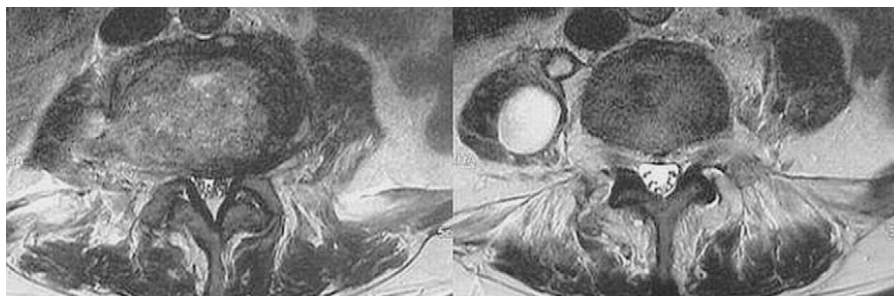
Magnetic resonance imagery, axial views showing discitis (left view) and abscess in the muscle (right view) (patient 1).
